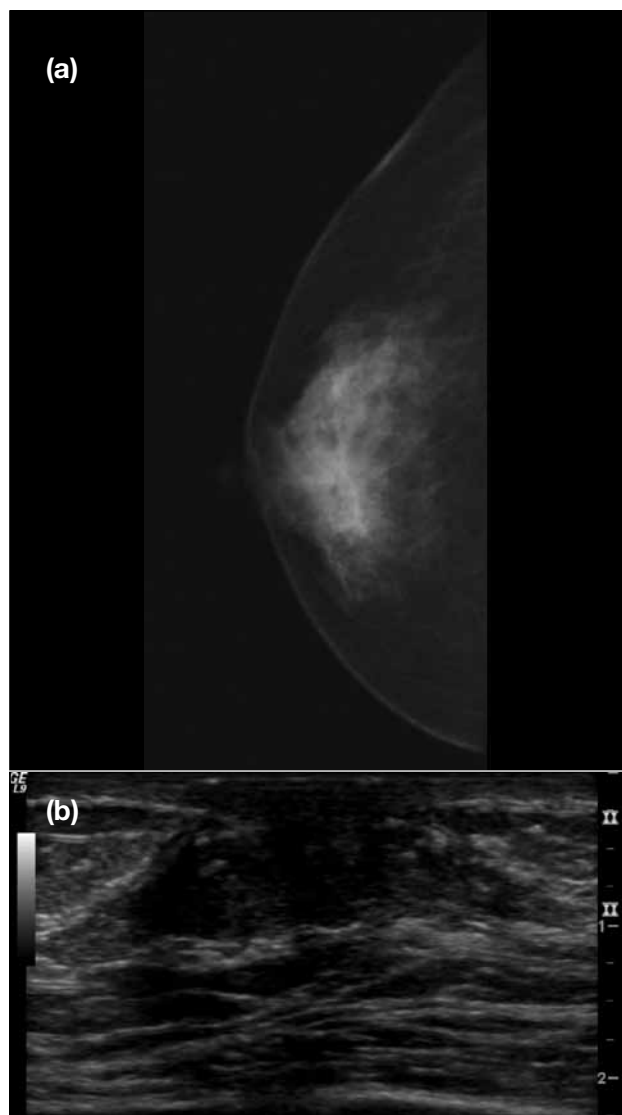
Diffuse glandular gynaecomastia: (a) Craniocaudal mammogram showing a diffuse density with both dendritic and nodular features. (b) Supplementary ultrasound reveals a heterogeneous breast with both dendritic and nodular features.
